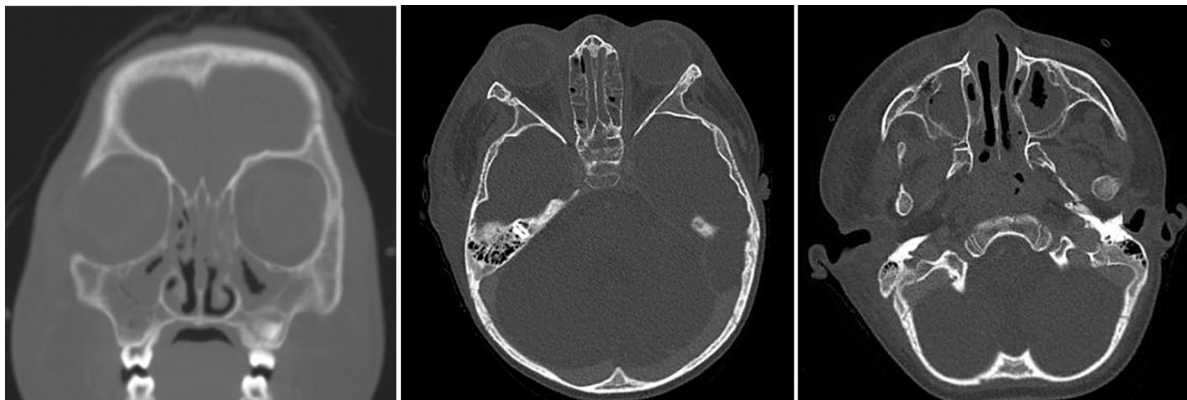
Initial CT prior to any surgical intervention.
